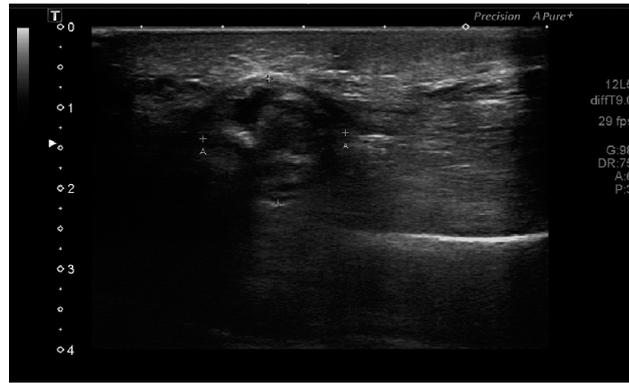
Doppler ultrasonography showed an inhomogeneous mass in the plantar area of the left foot.
